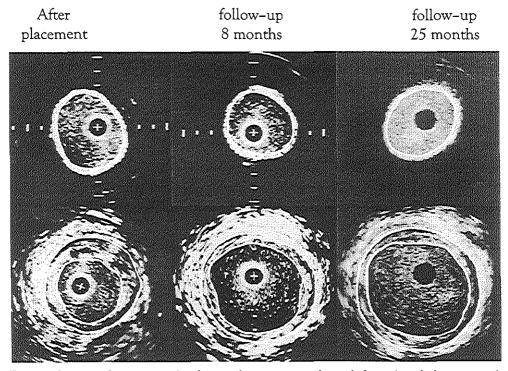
Corresponding intravascular ultrasound cross-sections obtained after endograft placement, and at 8 and 25 months follow-up from the distal endograft edge (upper panel) and anastomotic segment (lower panel) of a patient treated with an ePTFE endograft. The inner contour displays the lumen area (endograft) and the outer contour the vessel area. The endograft did not change at follow-up. At the anastomotic segment an increase in both lumen and vessel area was seen at 8 months follow-up, which tended to stabilize at 25 months follow-up. Plaque area increase encountered in both follow-up periods was similar. (+ = catheter; calibration = 1 mm).
